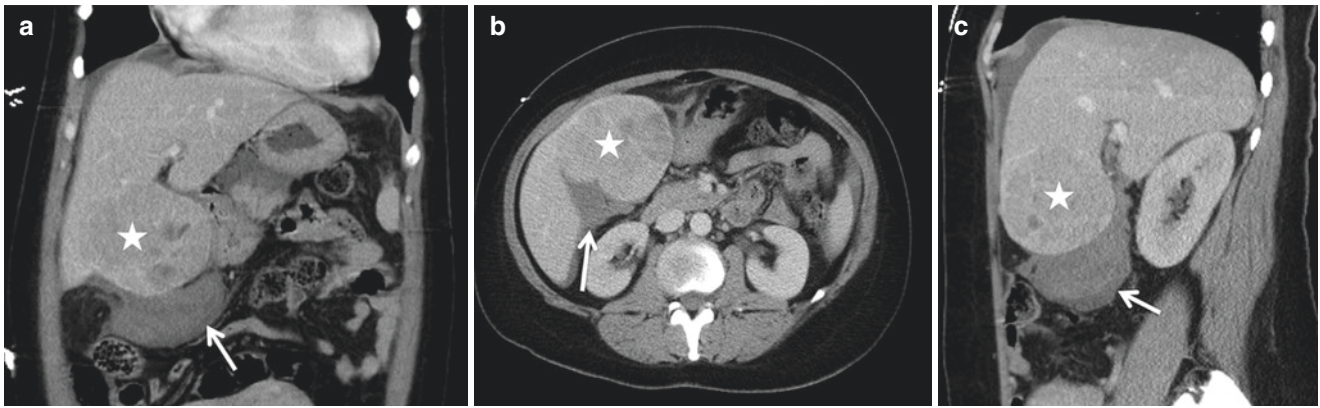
A 47-year-old patient presented to the emergency department with acute-onset right upper quadrant pain. Coronal (a), axial (b), and sagittal (c) contrast-enhanced CT images of the abdomen reveal a heterogeneously enhancing exophytic hepatic mass (*asterisk*) arising
